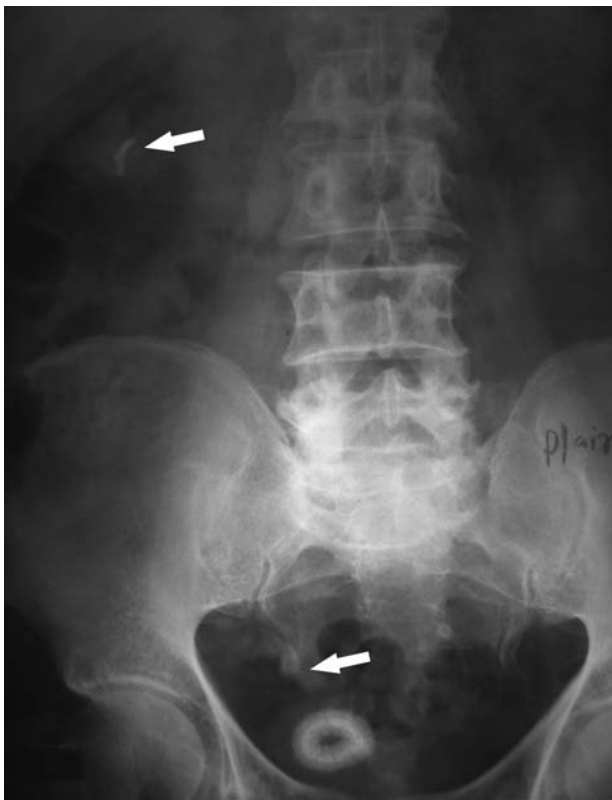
Plain abdominal radiography shows coiled double J stent in the kidney and bladder region with encrustation (arrows).
